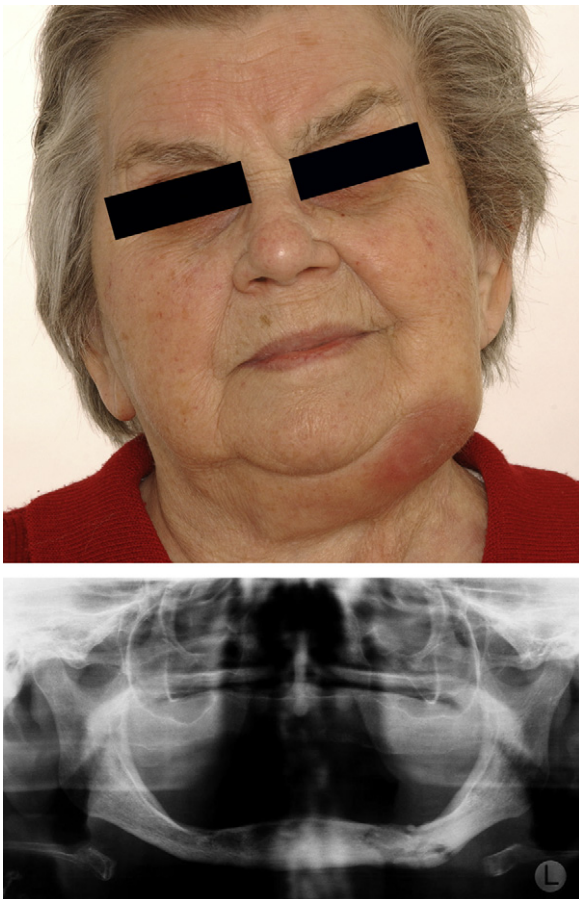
Clinical picture and panoramic radiograph of a female patient suffering from an acute abscess due to BP-associated osteonecrosis of the left lower jaw under oral BP intake.
